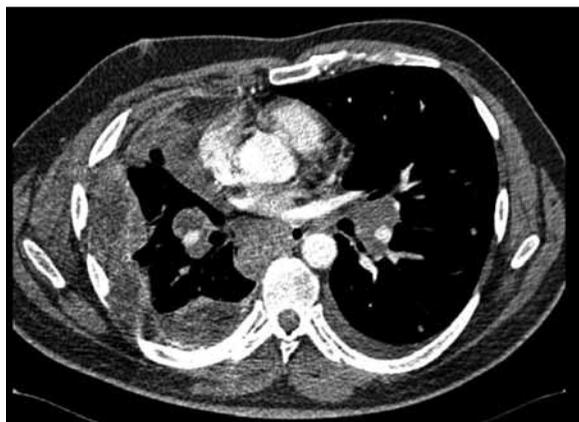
Chest CT, axial plane. Lymph node metastases.
